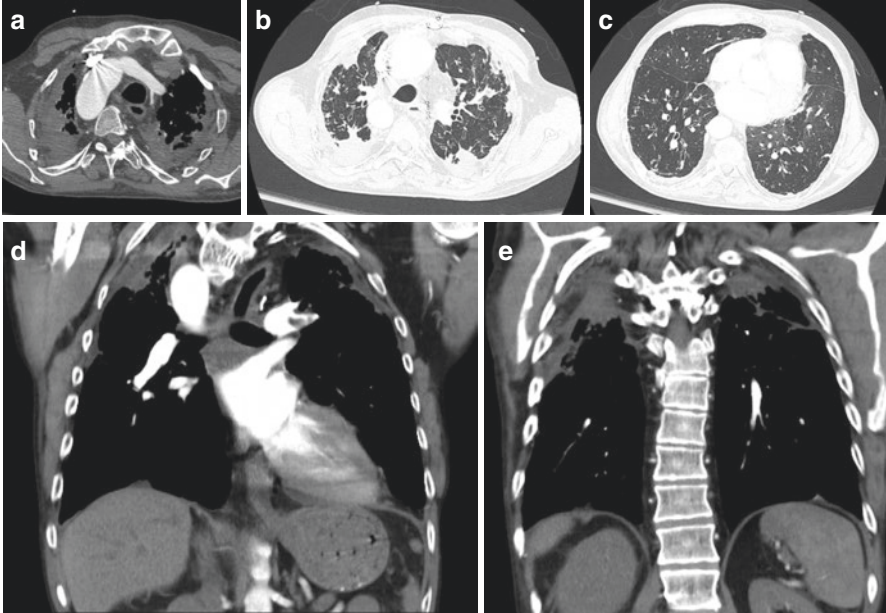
(a–e) A 56-year-old male status post DLT with serial axial (a–c) and coronal (d, e) CT images demonstrating upper lobe predominant fibrosis and pleural thickening with sparing of the bases where additional features of bronchiolitis obliterans can be appreciated. There is increased recognition of pleuroparenchymal fibroelastosis as the etiology of this pattern of fibrosis in lung transplant patients and the imaging appearance in this case are typical of that entity
